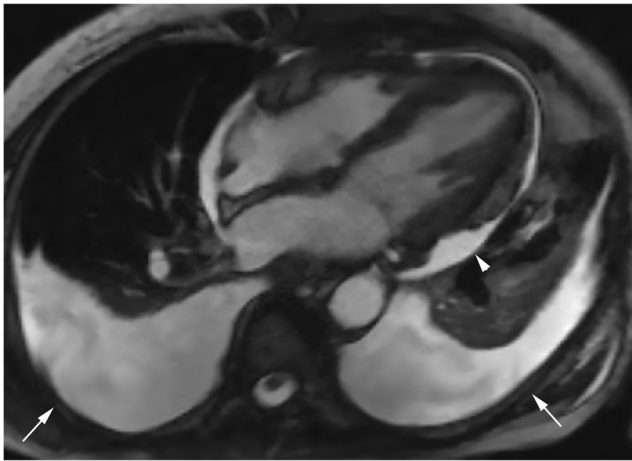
T2-weighted cardiac MRI exam of an SLE patient with serositis shows a small pericardial effusion (*arrowhead*) and moderate bilateral pleural effusions (*arrows*). MRI magnetic resonance imaging, SLE systemic lupus erythematosus
